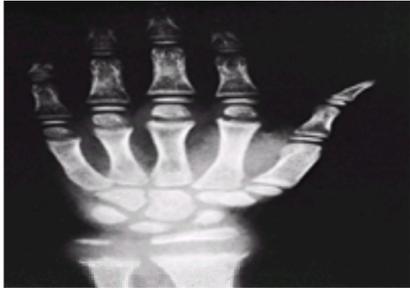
Changes in the epiphyseal plates of the wrist and hand are seen in this radiograph of an 8-year-old child with florid rickets. The distal radial and ulnar epiphyseal lines are markedly increased in axial height and show cupping; the zone of provisional calcification is absent. The changes in the slower-growing physes of the more distally placed bones are less marked, emphasizing the fact that rickets is a disease of the growing skeleton (in contrast to osteomalacia), and if the physal regions grow slowly, the findings are much less prominent.
